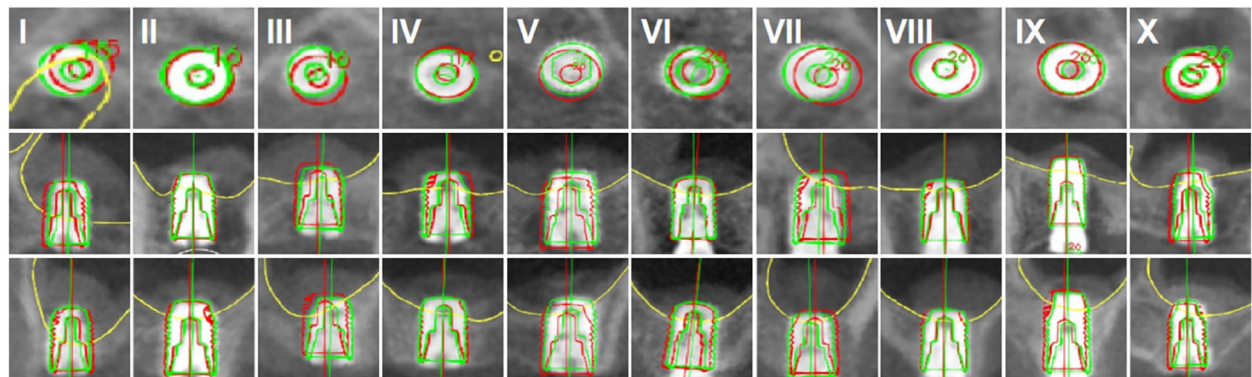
CBCT fusion images of the planned and placed implants for each case. The transverse, coronal, and sagittal planes are indicated by the first, second, and third lines, respectively. Planned implants are outlined in red, and the placed implants are outlined in green
